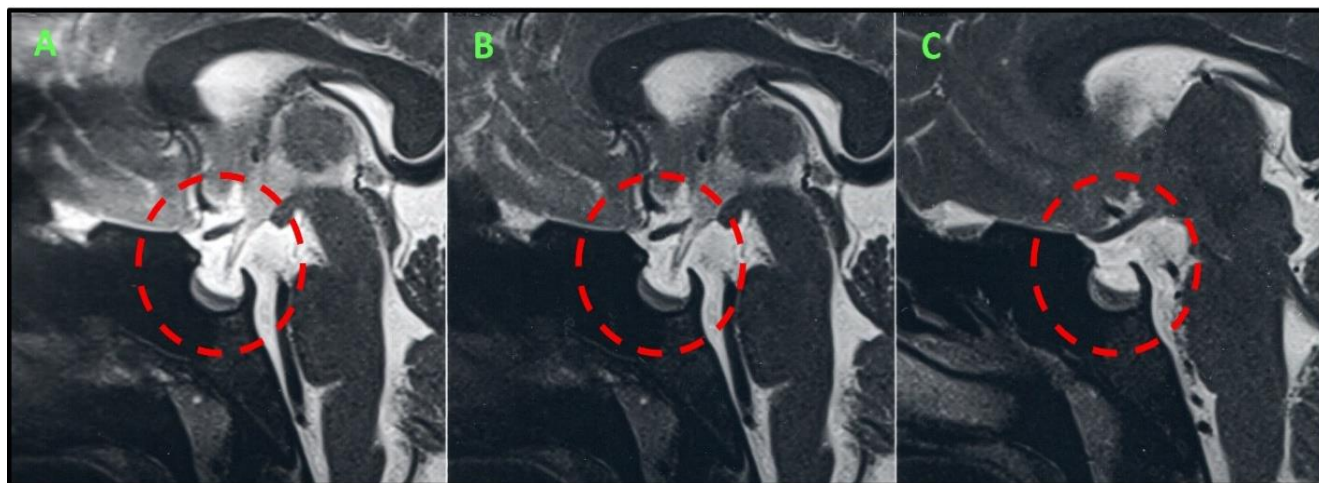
(A-C): MRI image of Sella.
